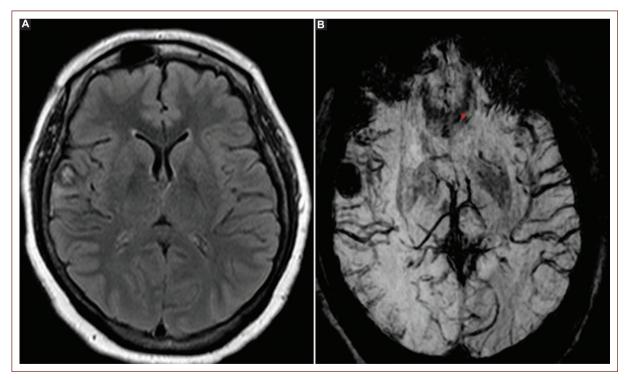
Fluid-attenuated inversion recovery magnetic resonance imaging (MRI) (A) shows a hypointense lesion with an isointense center (popcorn appearance) and perilesional edema in the right parietal operculum. Susceptibility-weighted angiography MRI (B) reveals a hypointense lesion in the right parietal operculum.
